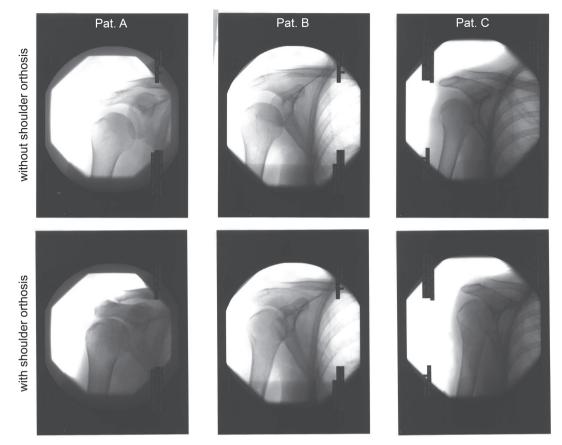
Anterior-posterior X-rays in standing for 3 patients (A, B, C) without (top figure) and with the orthosis (lower figure). The orthosis reduced the vertical displacement of the glenohumeral joint.
